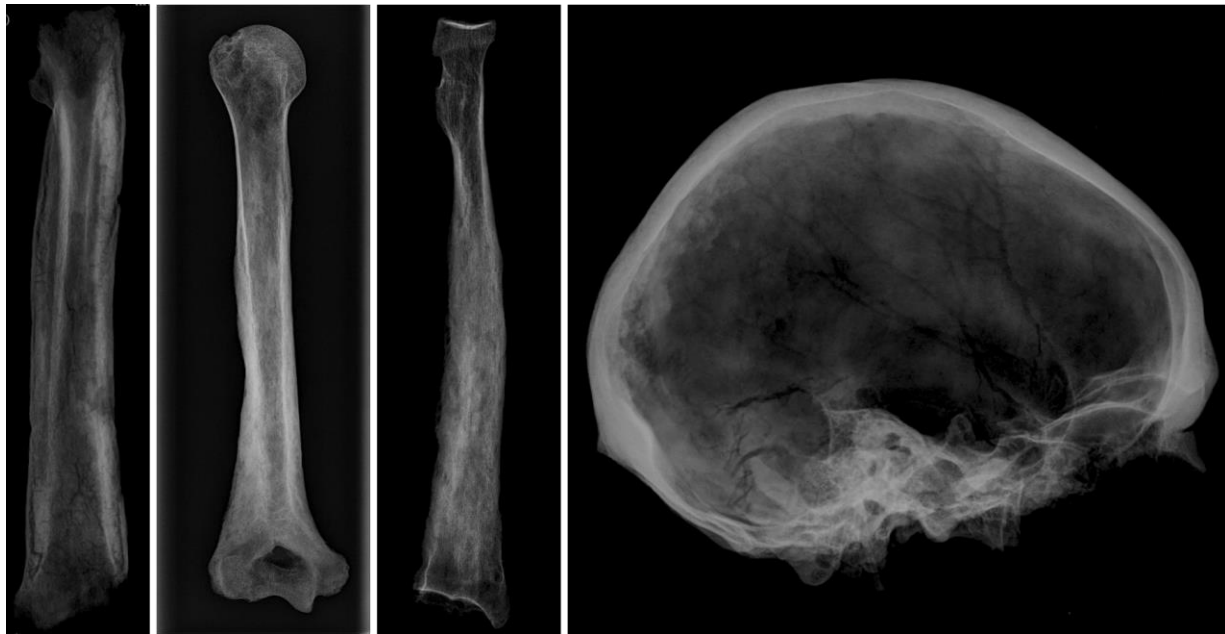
Radiographs showing skeletal changes observed in the older adult male (SKR 174) with Paget's disease, a differential diagnosis of skeletal fluorosis, from Skriðuklaustur. From left: left femur (anterior), right humerus (anterior), right radius (anterior) and cranium (right lateral aspect). © Joe W. Walser III, National Museum of Iceland
